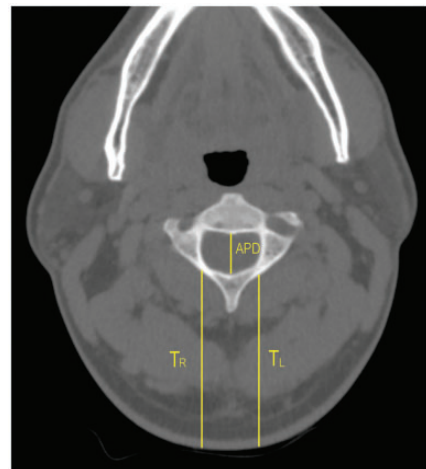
Computed tomography (CT) image of transverse section of cervical spine showing anteroposterior diameter of the vertebral canal (APD) and the thickness of the posterior cervical soft tissue (T). T was the mean distance from the midpoint of the lamina to the surface of the skin (i.e., the average length of T on the left side (T_L) and T on the right side (T_R).
